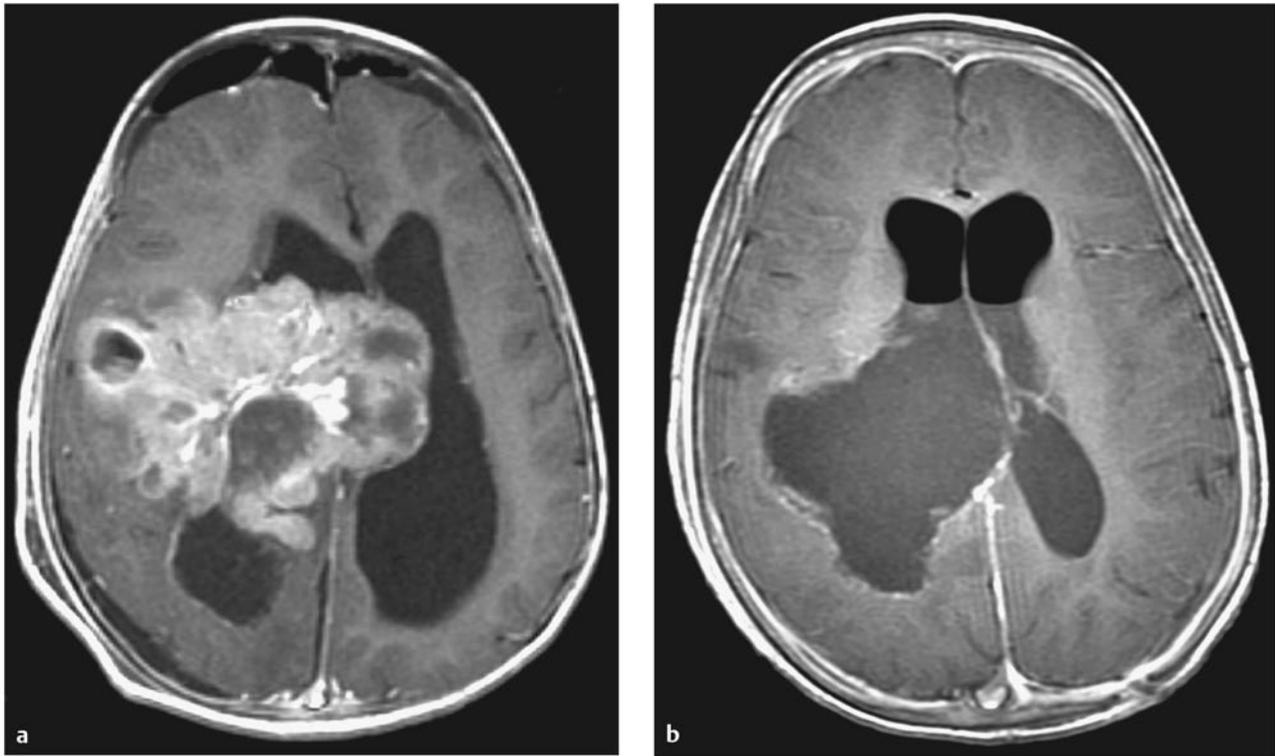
Ependymoma. (a) Preoperative and (b) postoperative axial magnetic resonance images following contrast administration in a 14-month-old boy with a supratentorial ependymoma. The tumor occupies a significant portion of the right cerebral hemisphere. The child underwent total excision of an anaplastic ependymoma at second-look surgery following adjunctive preoperative chemotherapy.
